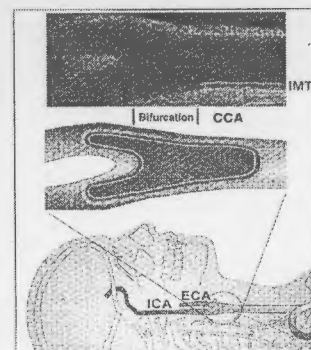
A clear B-mode ultrasound image of the measurement of the C-IMT of the far wall as detected using the computerized edge detecting system that uses algorithms to analyze ultrasound (doppler) images and calculate the IMT value. The two vertical grey lines indicate the width of the intima-media layer and the horizontal yellow lines measure the mean thickness of the IM layer. The two small blue lines within the yellow lines indicate the maximum IM layer.
